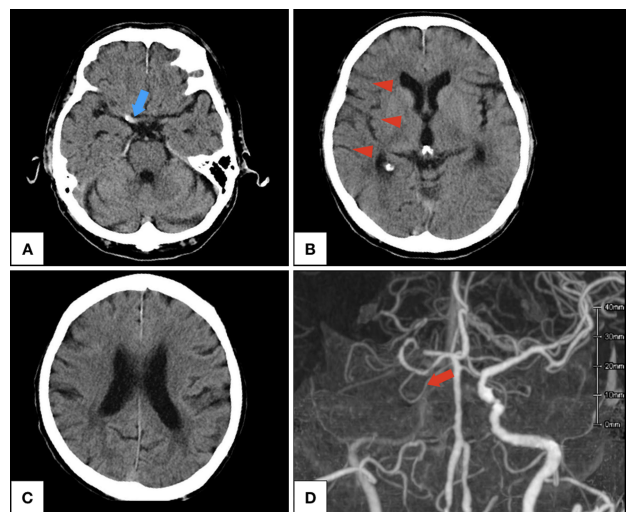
Head CT on admission. (A) The plain head CT shows a right hyperdense middle cerebral artery (blue arrow). (B) The plain head CT shows hypoattenuating brain tissue in the right hemisphere (red arrow heads). (C) The plain head CT shows no other hypoattenuating brain tissue in the right hemisphere. (D) CT angiography shows right internal carotid artery terminus occlusion.
